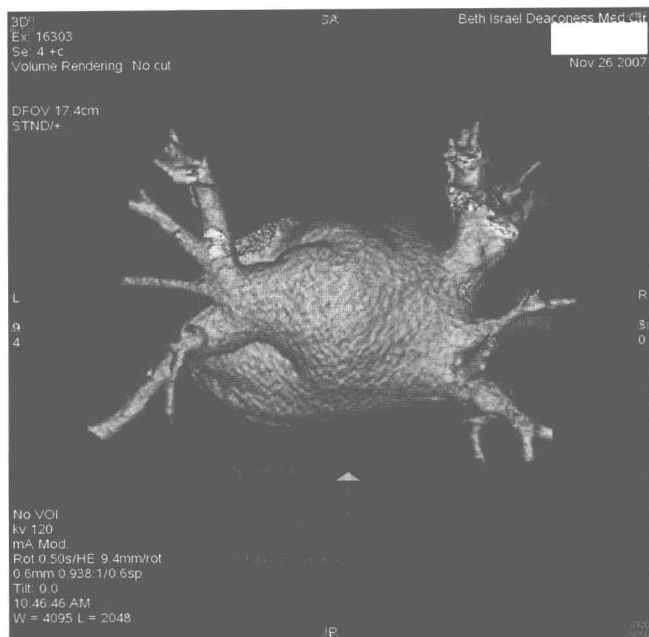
Computed tomographic (CT) angiogram of the posterior aspect of the left atrium. (See color insert.)
